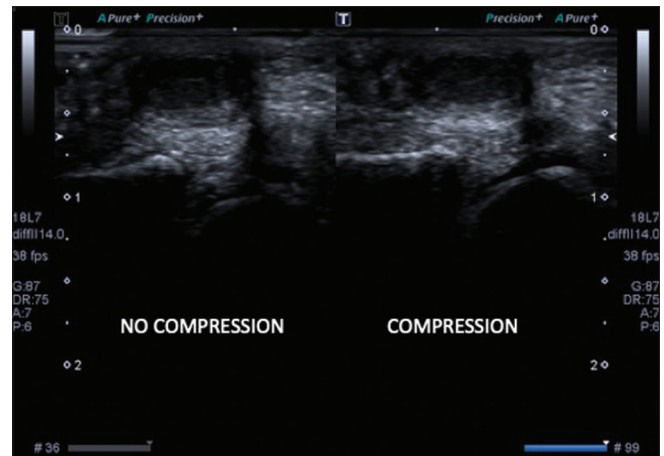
Ultrasound dual image of the mass without and with direct probe compression
